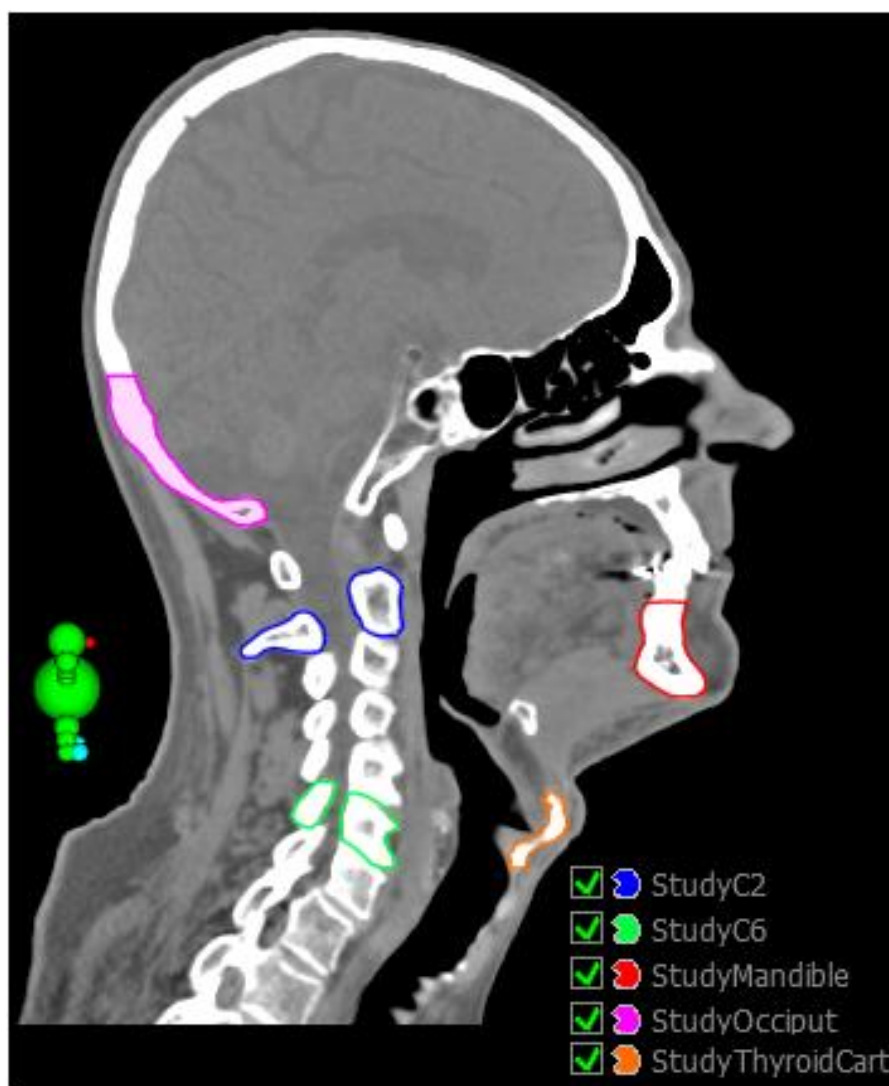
Sagittal view of a study planning CT, with bony landmark regions-of-interest used to evaluate setup accuracy of the 3D printed immobilization.
